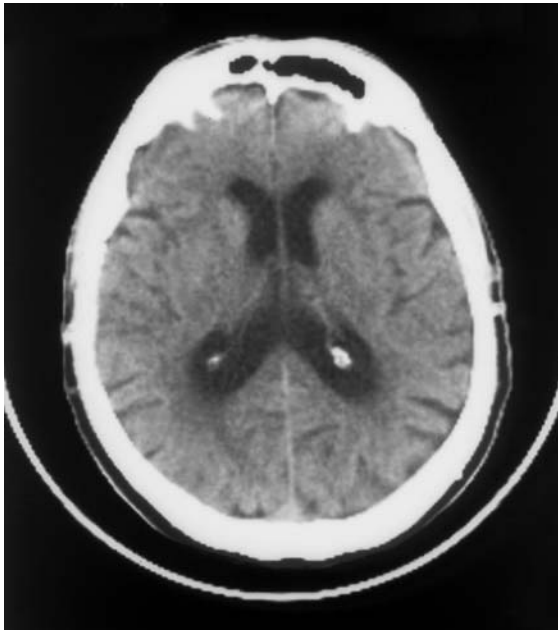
Ventriculomegaly with passive cerebral atrophy. Axial CT shows passive cerebral atrophy associated with ventriculomegaly.
